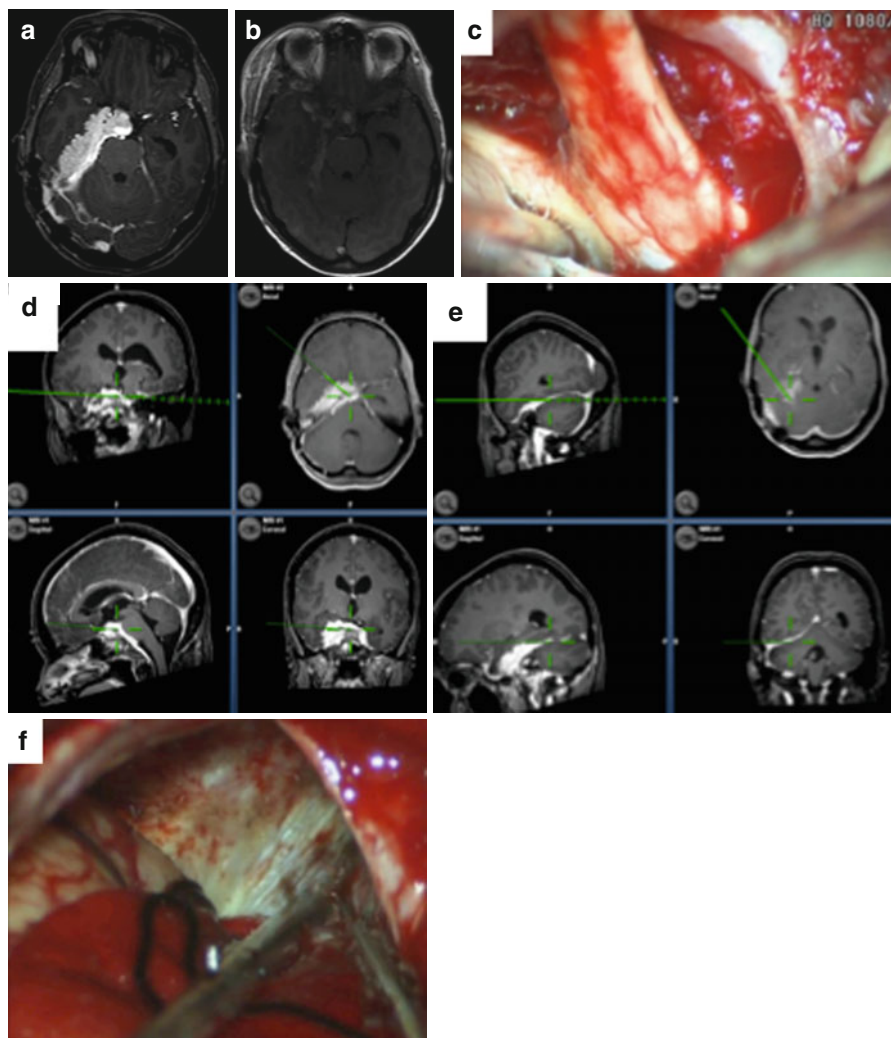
Neuronavigation in skull base meningiomas supports radical surgery in intradural space: combined frontotemporal and subtemporal approach to completely remove the intradural part of a petroclival meningioma. (a, b) Pre- and postoperative MRI scan; (c) 2 intraoperative view of neuronavigation in the region of the optic chiasm, tumor under the chiasm; (d) pointer at chiasmal region after tumor removal; (e) pointer in the posterior part of tumor extension as shown in the right portion of fig (f)
